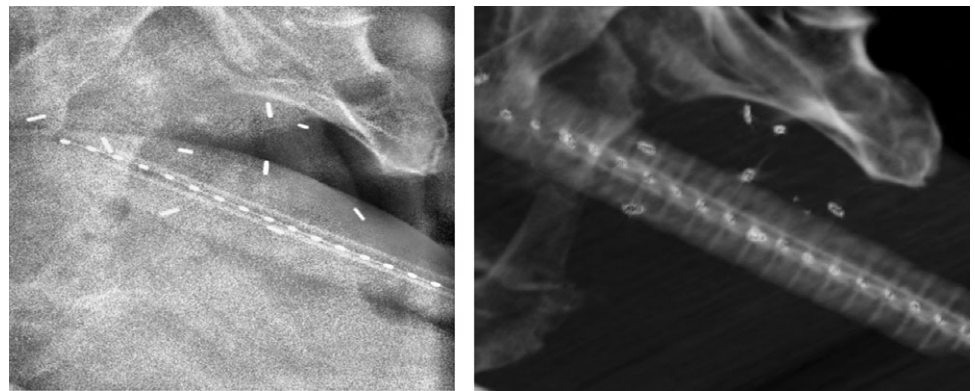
Radiographic image obtained from X-ray imaging system in the first column and digitally reconstructed radiograph in the second column by the ExacTrac system from the CT images.
